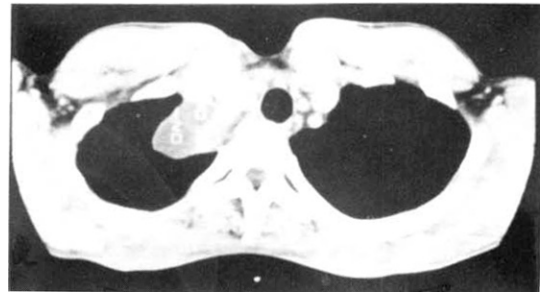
Chest CT scan revealed large multi-cystic mass lesion on the right paratracheal area which was attached to the lower pole of the right thyroid gland, displaced the superior vena cava anteriorly and extended to the level of the azygous vein.
